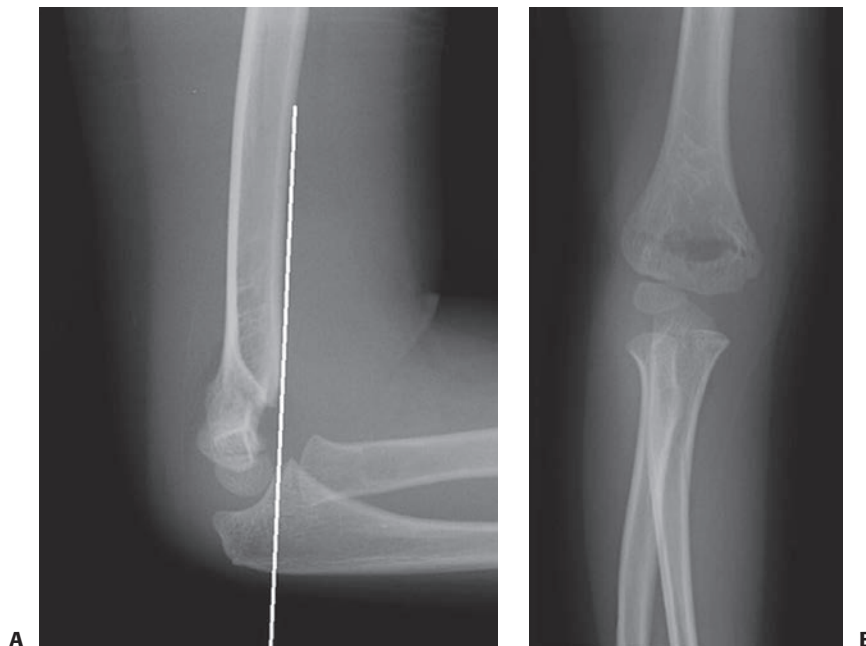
A: Type II SCH fracture with anterior humeral line anterior to the capitellum. B: AP radiograph of a type II SCH fracture in a 6-year-old girl. Note that Baumann's angle is intact.
